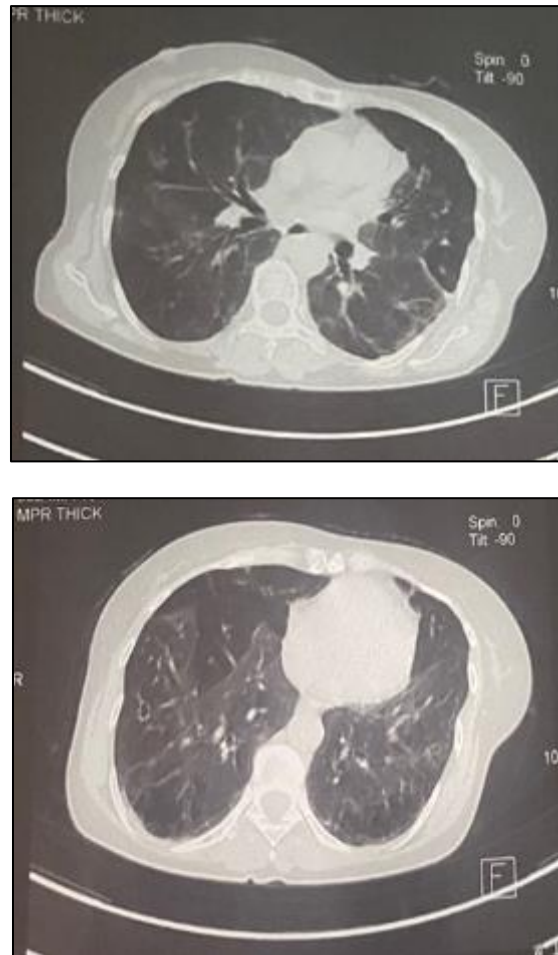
Chest CT scan in the parenchymal window showing a mosaic aspect
